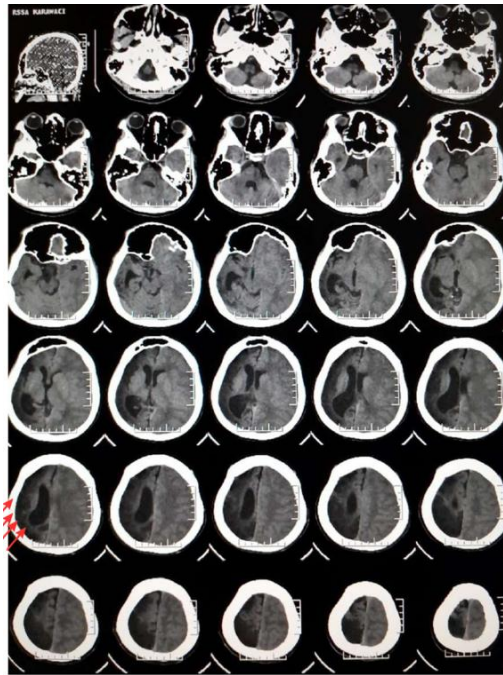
Non-contrast CT scan revealed large hypodense lesion expanded from the frontotemporoparietal of the right brain, the left lateral ventricle had disappeared, the midline was shifted to the right.
